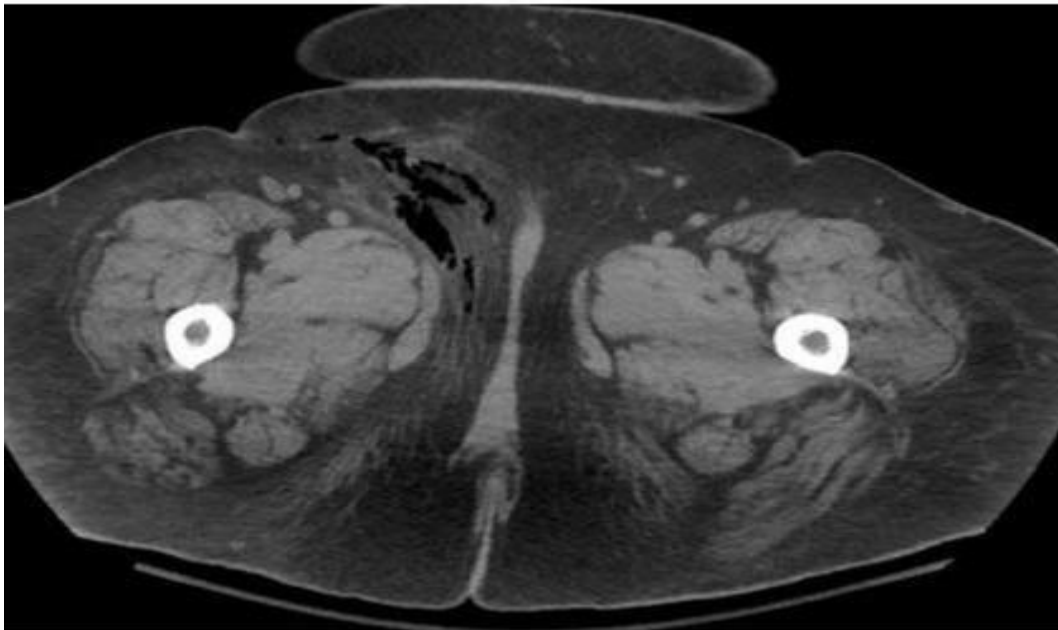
CT shows Necrotising fasciitis of right lower limb extending to abdominal wall shows gas within tracing along the fascial plane.
